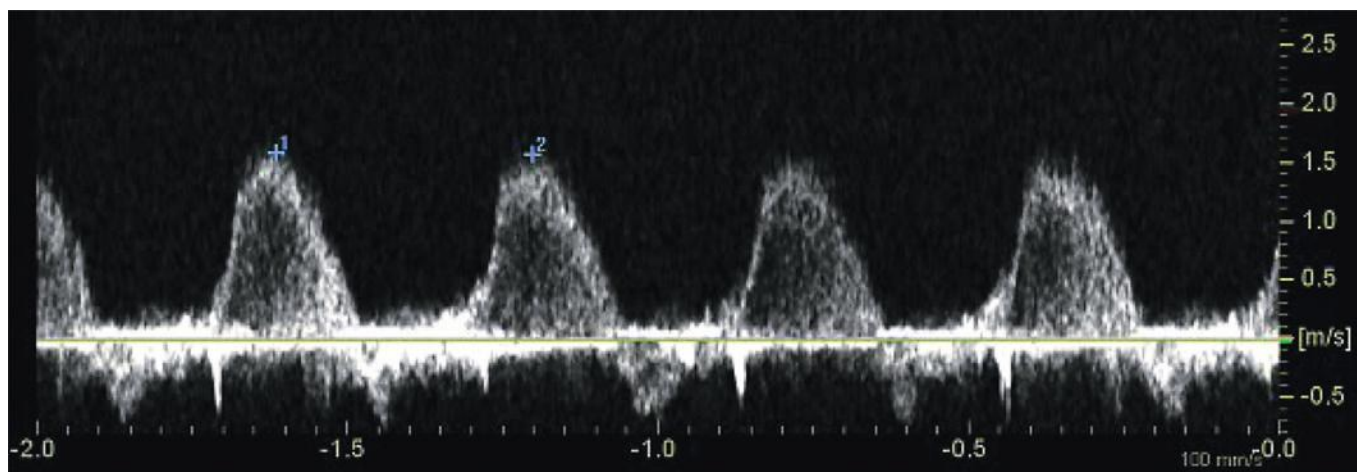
Spectral Doppler in a first trimester fetus with severe tricuspid valve regurgitation. Note that the duration of regurgitation extends for over half of systole.
